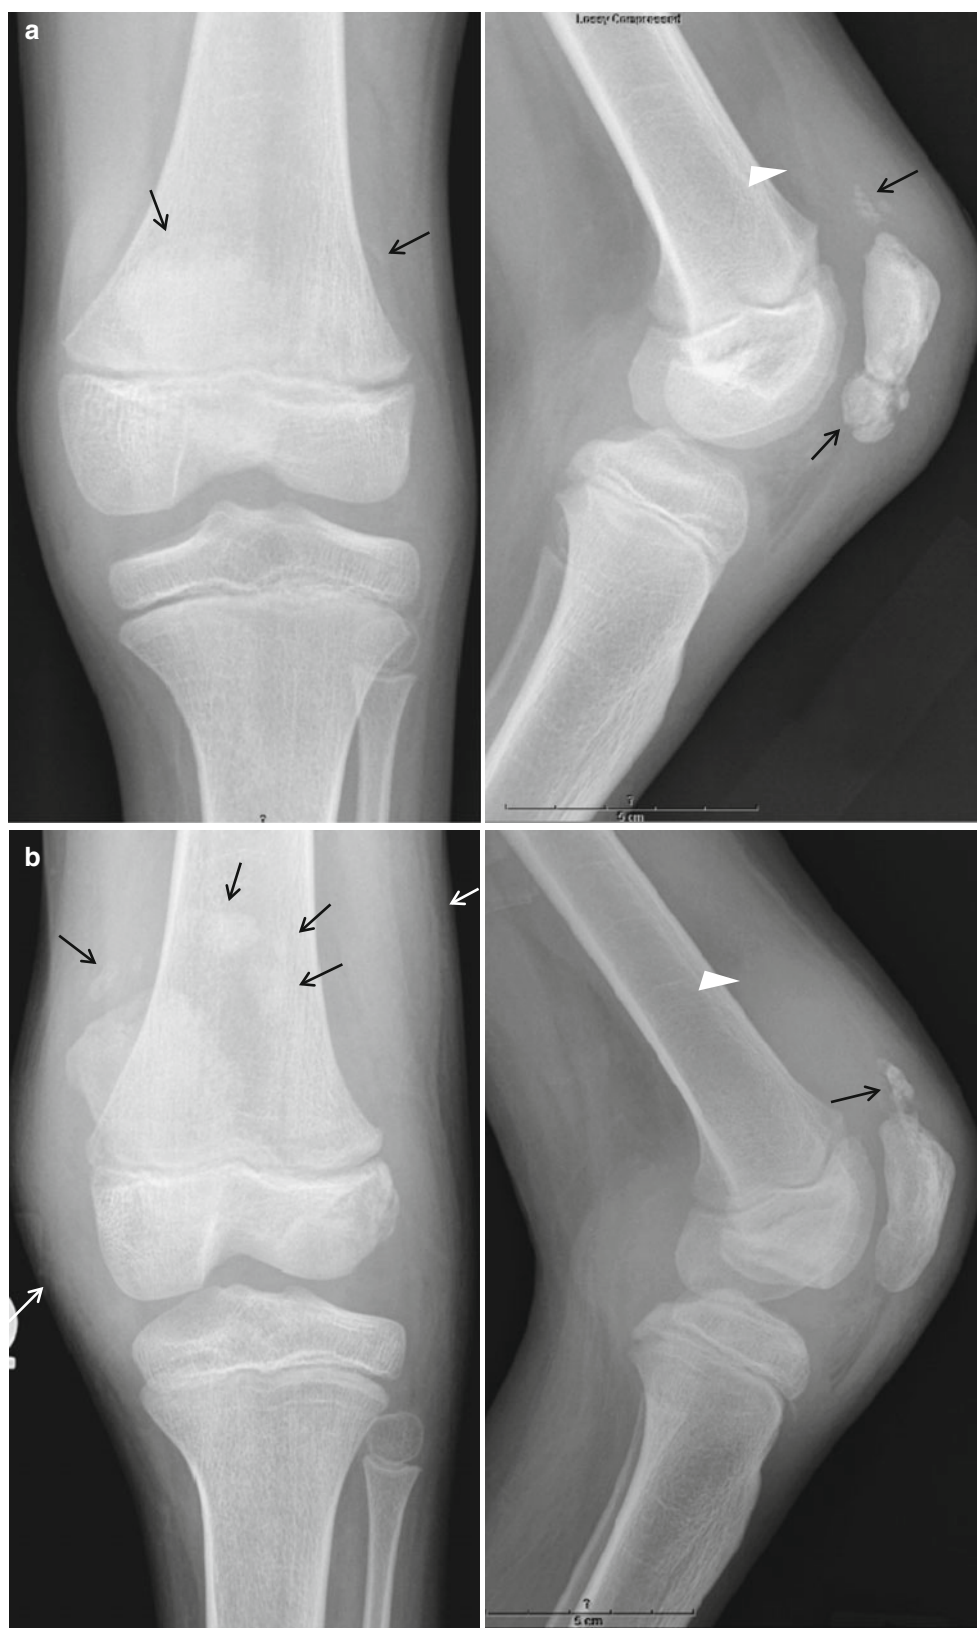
A 6-year-old boy with myelomeningocele and neuropathic joint. (a) Initial radiographs of the knee joint demonstrate fragmentation of the patella (arrows) and a large joint effusion (arrowhead). (b) Follow-up radiographs 8 months later demonstrate soft tissue swelling (white arrows), progressive fracture of the patella (arrows), and a large
